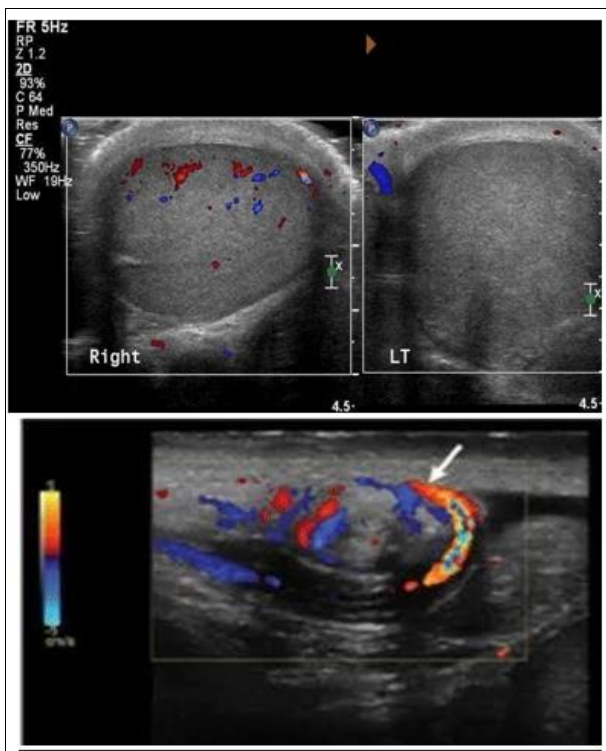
A, B&C: scrotal ultrasound revealed
